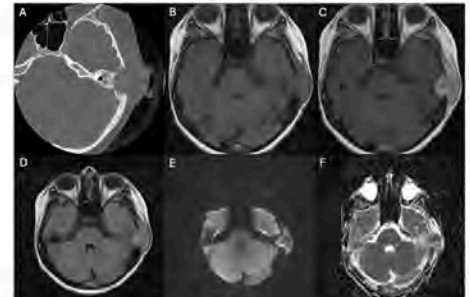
10-year-old boy with left mastoid pain and swelling. A. Axial CT of the left temporal bone shows a well-circumscribed lucency in the left temporal bone associated with this mass. B. Axial T1 pre-contrast shows an intermediate signal intensity mass in the left mastoid region. C. Axial T1 post-contrast shows enhancement of this mass. D. Axial T2 sequence demonstrates well-circumscribed left temporal bone mass with intermediate T2 signal. E. DWI sequence shows no restricted diffusion associated with this mass, confirmed on F. ADC map.
